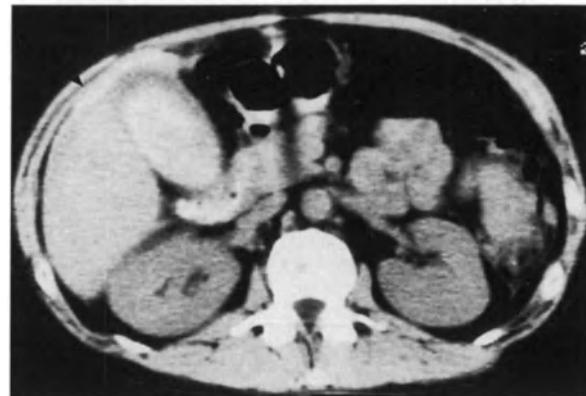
CT scan unenhanced. Stab wound to liver. High density fresh blood in gallbladder and subcapsular hematoma of liver (arrow).
